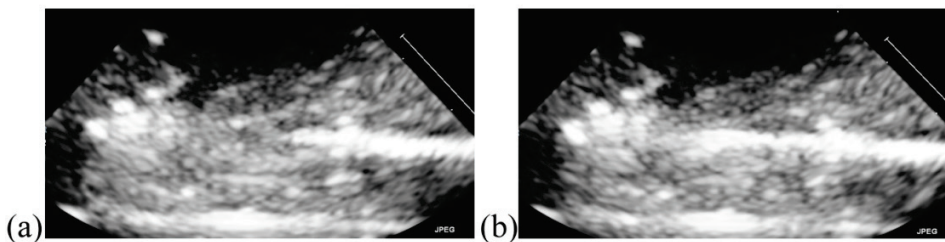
Ultrasound images of the needle inside kidney. (a) The initial frame and (b) the final frame of the video taken during the motion of the needle inside the kidney.
